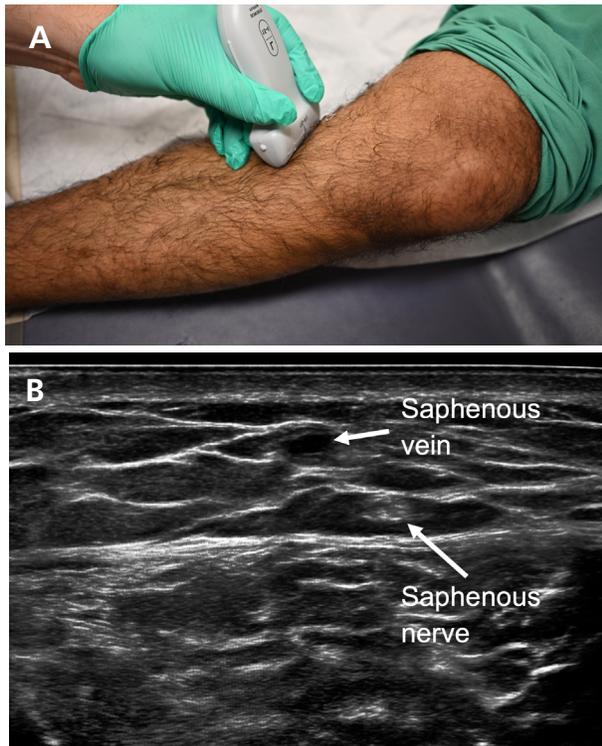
A) Patient and ultrasound positioning to visualize the saphenous nerve. B) Ultrasound visualization of the saphenous nerve via the saphenous vein.
